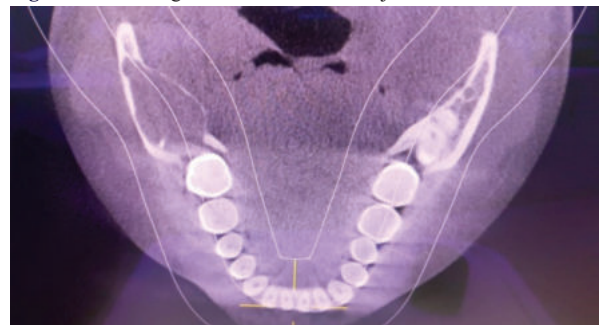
CBCT showing lesions on either side of jaw
